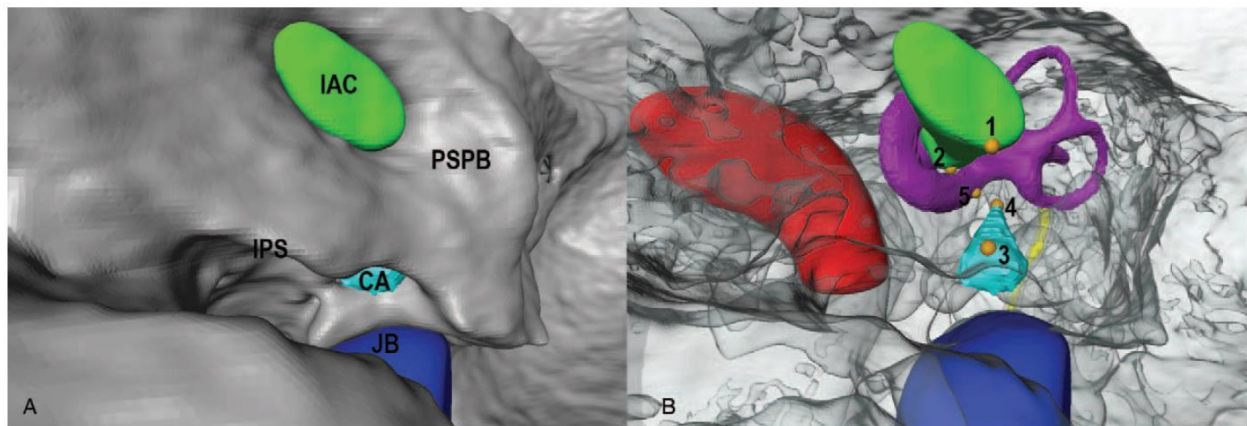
A 3D model based on segmentation from temporal bone HRCT (right side). Green: internal auditory canal (IAC); light blue: cochlear aqueduct (CA); purple: bony labyrinth; yellow: facial nerve; red: internal carotid artery; blue: jugular bulb. Star guide – S: superior; I: inferior; A: anterior; P: posterior. Figure A: Surgical perspective. Figure B: Medial-to-lateral perspective; 1: medial lower limit of the IAC; 2: lateral lower limit of the IAC; 3: medial end of the visual part of the CA; 4: lateral end of the visual part of the CA; 5: virtual opening of the CA into the round window.
